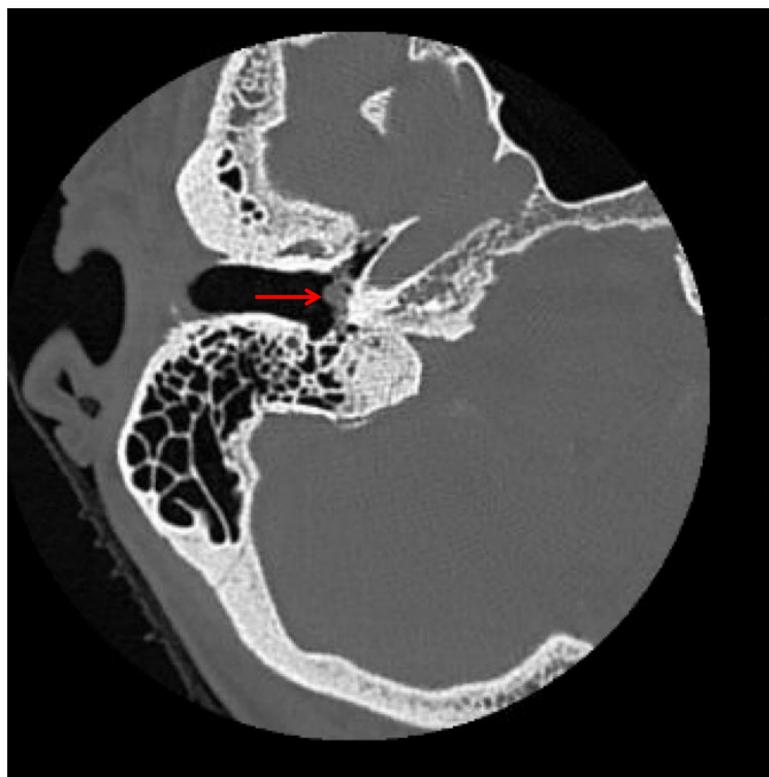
High-resolution CT of the temporal bone demonstrated a 3 × 3 mm soft-tissue lesion arising from the promontory, consistent with a glomus tympanicum tumor.
